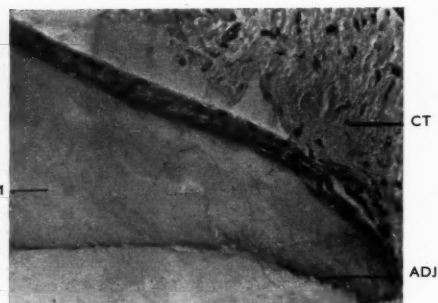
Decalcified section of gingival attachment area of erupted young premolar showing epithelial cells on chromophobic enamel matrix. Formic-methyl-alcohol decalcification. Ehrlich's hæmatoxylin and eosin. M, Chromophobic enamel matrix; CT, Connective tissue; ADJ, Amelo-dental junction. ($\times 260$.)
